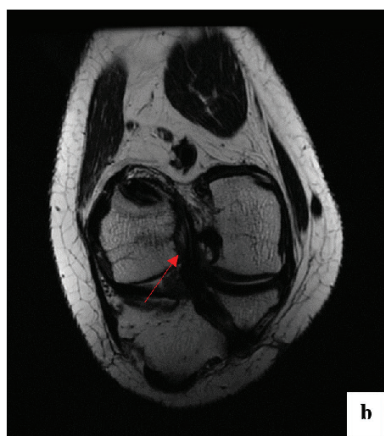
Magnetic resonance imaging of the right knee joint 4 months after surgery: a – minimal edema of the pararticular soft tissues (yellow arrow) and bone structures (blue arrow) remains on PD FS in sagittal projection; b – an increase in the MR signal from the graft on T2 VI in the oblique coronary projection (red arrow)
